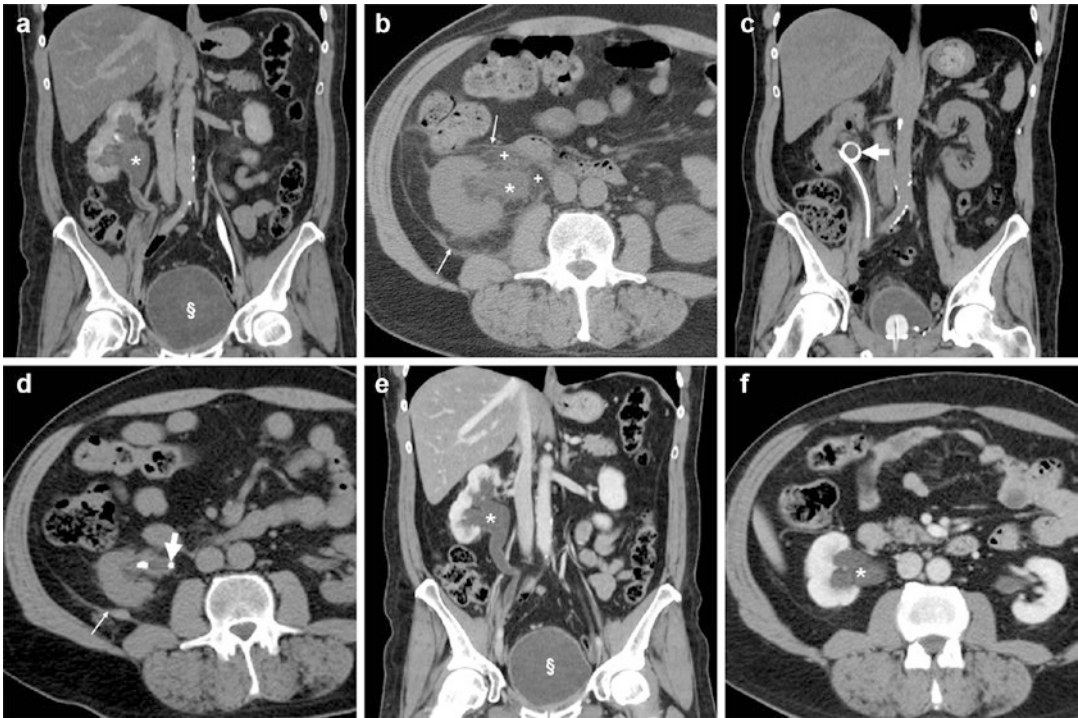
A 61-year-old male with recent radical cystectomy for bladder carcinoma and orthotopic neobladder (§) reconstruction, as documented by postoperative multidetector CT urography. Note right-sided hydronephrosis (*) with delayed contrast excretion. A year later, he was hospitalized for sepsis and acute renal failure. Unenhanced CT (b) showed stable dilatation of the right renal pelvis (*) with appearance of peripelvic and perirenal “fat stranding” (+) and of ipsilateral fascial thickening (thin
